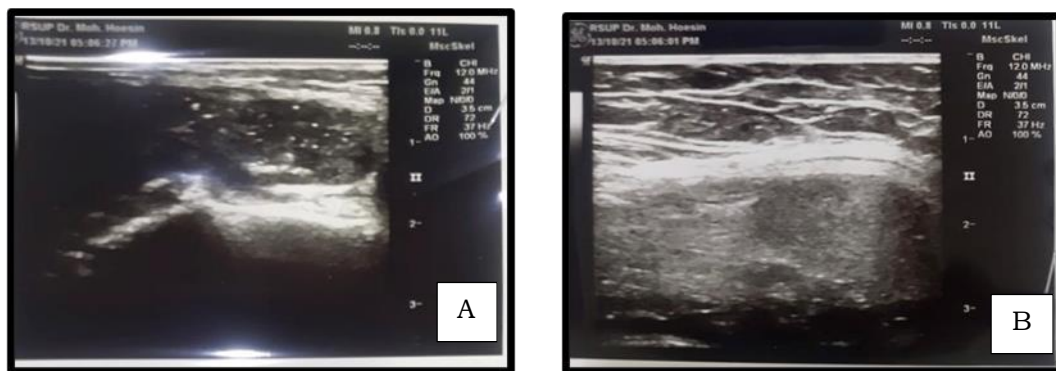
(A-B). Ultrasound imaging of the genu sinistra.
